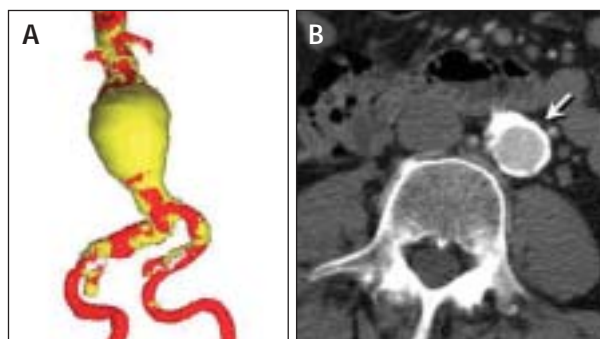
The combination of tortuosity (A) and dense circumferential calcification in the iliac arteries, as shown in the CT slice (arrow) (B), should be approached with caution even if there is no severe stenosis.
